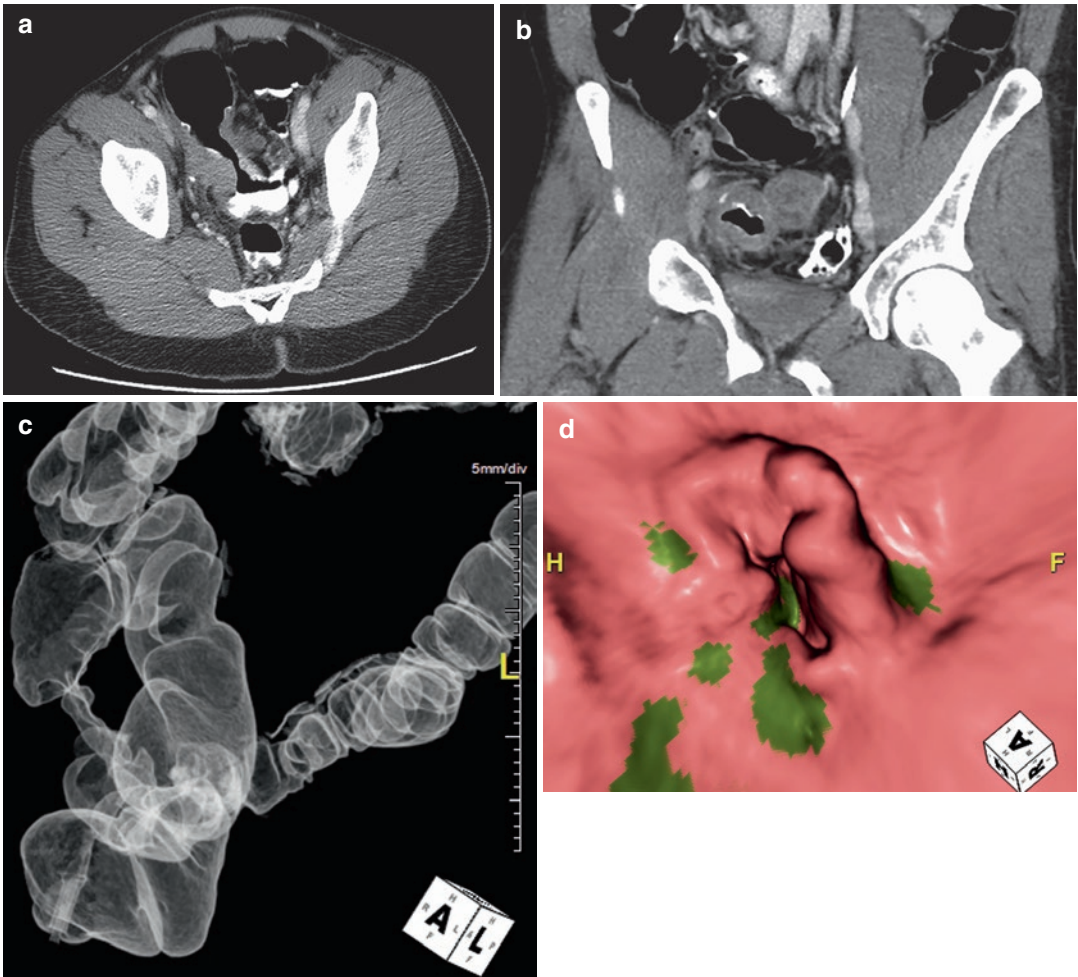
A 42-year-old male presented for CT colonography due to incomplete colonoscopy to the level of an obstructing sigmoid mass. (a) Supine axial CT shows circumferential bowel wall thickening in the sigmoid colon (*arrows*). (b) Coronal CT demonstrates a large mass/necrotic lymphadenopathy adjacent to the colon (*arrow*).
